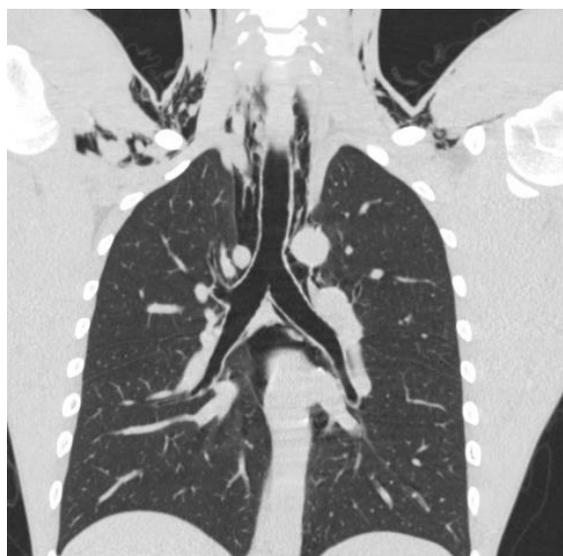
CT, tracheal rupture, coronal projection, pneumomediastinum
